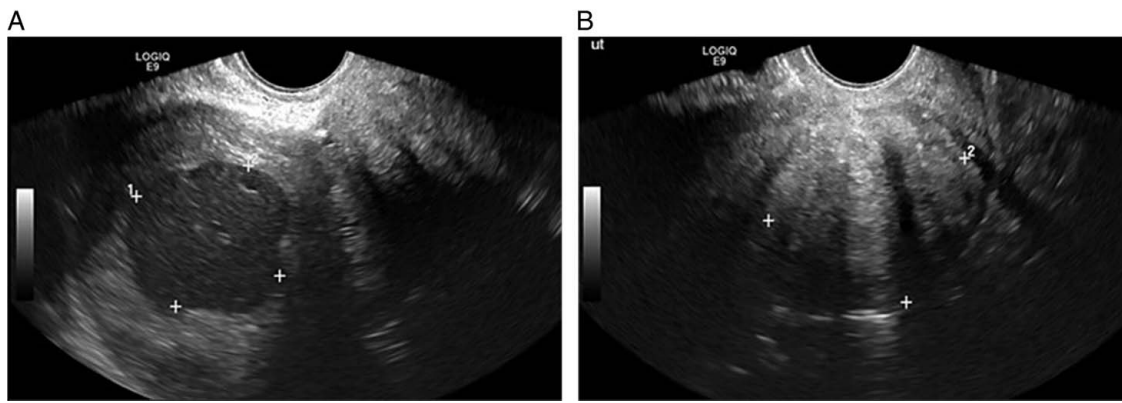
Transvaginal pelvic ultrasonography images showing a heterogenous hypoechoic area within the uterine cavity (A) and a posterior lower uterine fibroid involving the cervix (B).
